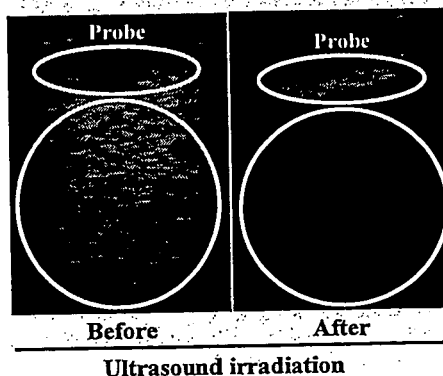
Ultrasound imaging of "Bubble liposomes" before and after ultrasound irradiation
